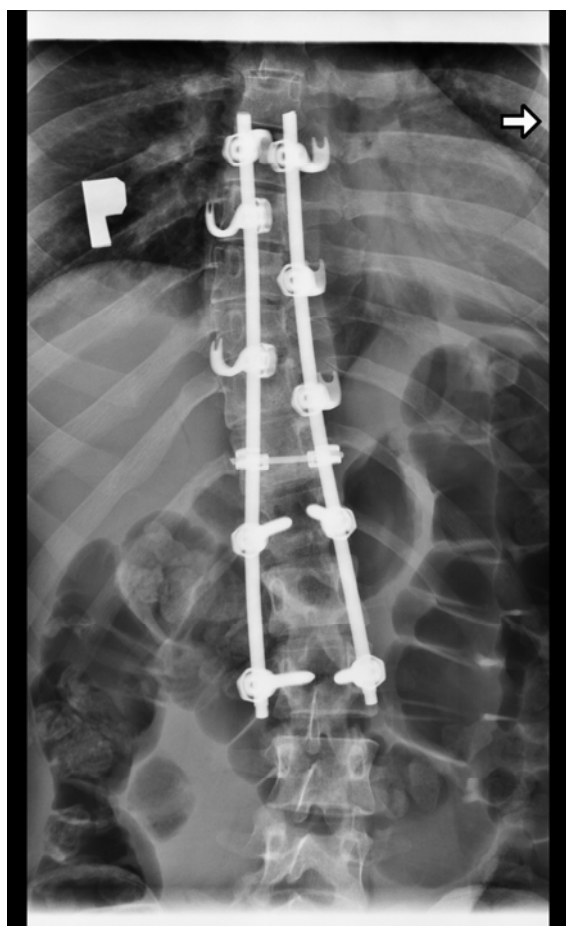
X-ray of the same patient (from Fig. 1) after surgical correction of scoliosis using the LFC implant
